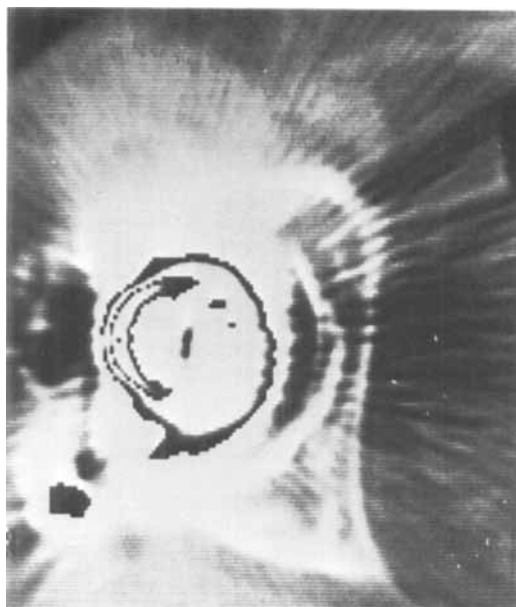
(Case 10). CT scan of the right hip demonstrating intact medial acetabular wall and good bone stock.
